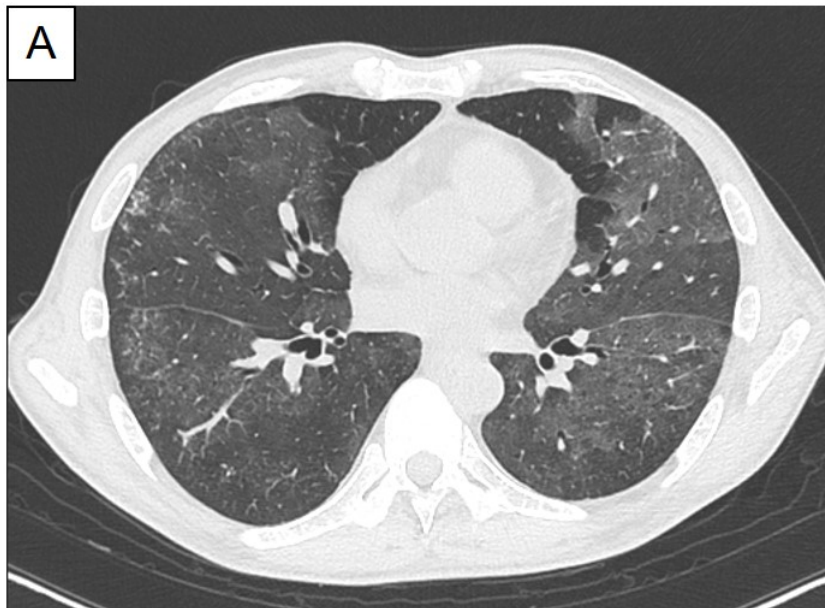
CT findings at the diagnosis of non-IPCs
